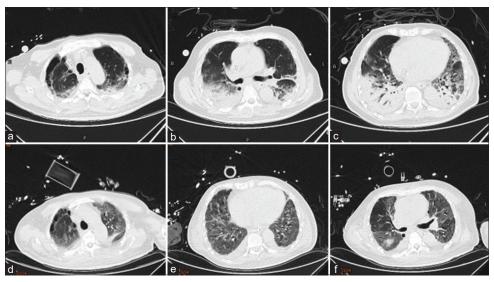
(a-c) Computed tomography of chest on day 14 before prolonged prone. (d-f) Computed tomography of chest on day 45 after weaning ECMO. ECMO = Extracorporeal membrane oxygenation
